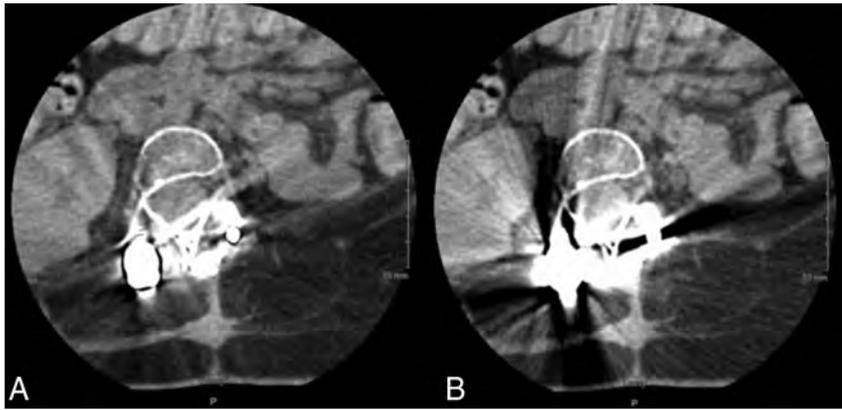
Axial lumbar CT images of a 15-year-old boy with spinal muscular atrophy type II who underwent posterior spinal fusion of T2–L5 due to severe scoliosis. *A*, MAR images demonstrating improved visualizations of soft tissues surrounding the hardware. *B*, Uncorrected images show artifacts covering soft tissues surrounding the hardware.
